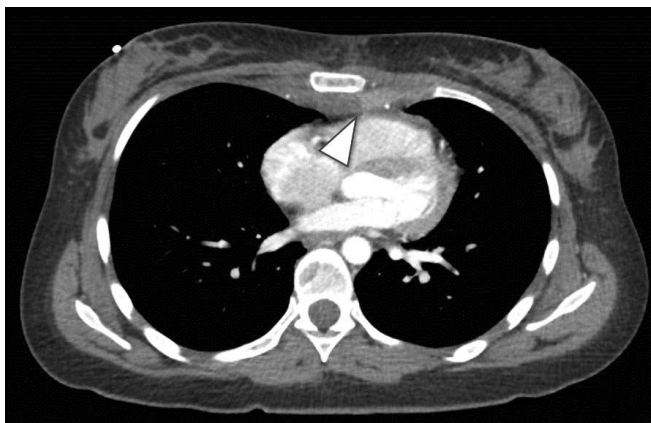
22-year-old female, fall from height (5 metres). Axial CT image shows a posterior dislocation of the rib; the medial end of the rib is locked behind the sternum. This injury type is also called separated rib or sternocostal dissociation.
